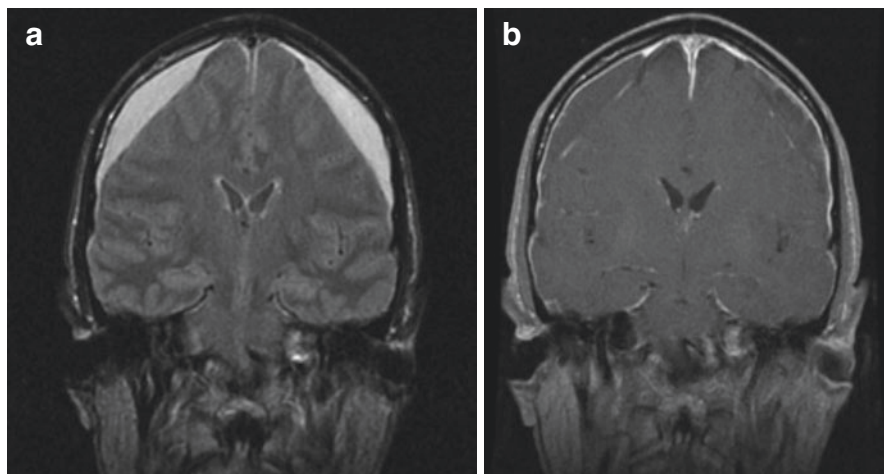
Coronal MRI brain findings for intracranial hypotension. (a) FLAIR imaging revealing bilateral chronic subdural hematomas with compression of the frontal lobes. (b) T1 contrast weighted imaging with diffuse dural enhancement
